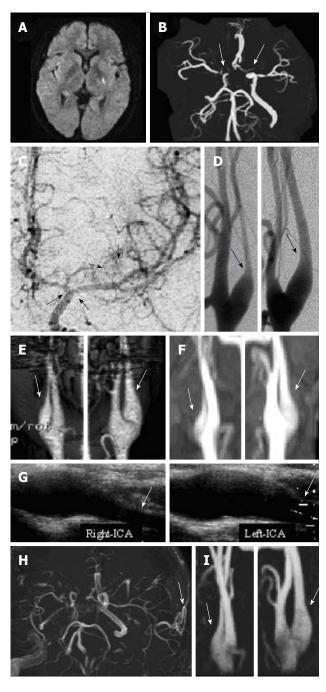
Imaging results. A: Diffusion-weighted magnetic resonance imaging three hours after the onset of right hemiparesis revealed a hyperintense area in the posterior limb of the left internal capsule; B: Magnetic resonance angiography (MRA) showing bilateral severe stenosis of the distal portion of the internal carotid artery (ICA) and proximal portions of the middle cerebral artery (MCA) and anterior cerebral artery (ACA); C: Left carotid angiography (anteroposterior view), showing Moyamoya-like vascular changes around the circle of Willis (black dotted arrows) as well as stenosis of the distal left ICA and proximal left MCA and ACA (black arrows); Bilateral champagne bottle neck (CBN) signs at the proximal ICAs (arrows) were observed with D: Digital subtraction angiography; E: Three-dimensional computed tomography angiography; and F: Ultrasonography; G: MRA in the euthyroid state, showing no changes in the bilateral CBN signs (white arrows); H: MRA at four years after superficial temporal artery to MCA anastomosis, showing that the anastomosis remained patent (white arrow); I: No change was observed in the bilateral CBN signs after four years (white arrows)
